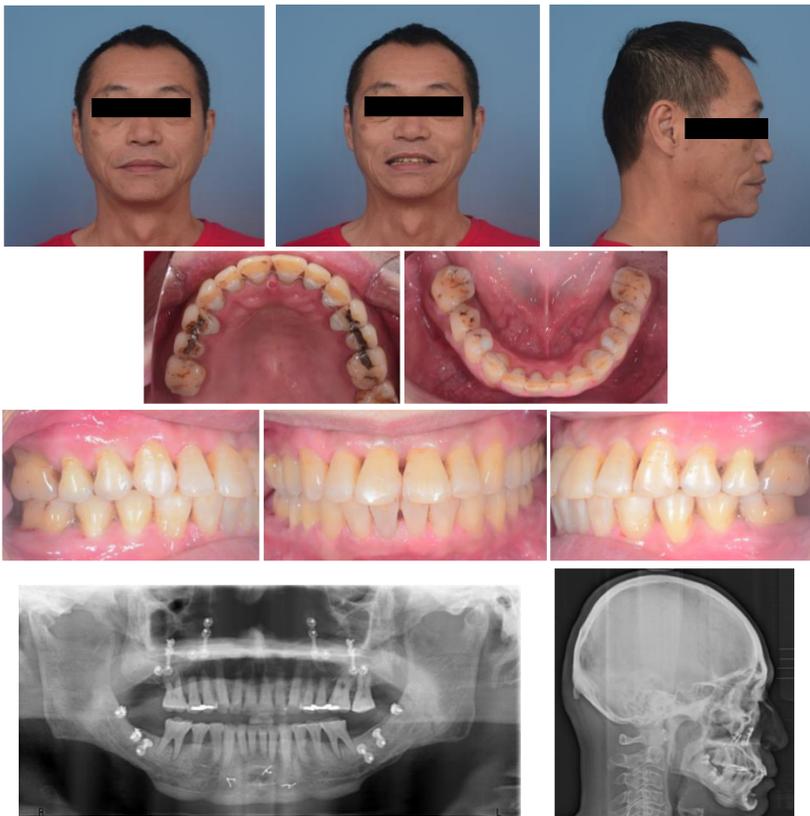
Post-treatment clinical evaluation, photos and radiographs at the debonding visit. The total treatment duration was 12 months.
